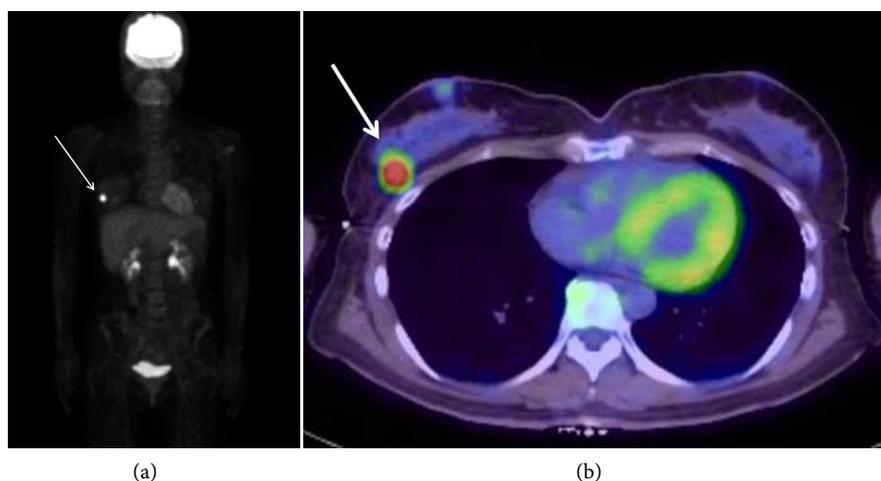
A 48-year-old woman with triple-negative invasive ductal cancer (17 mm; ER 0%, PR 0% HER2 0, Ki-67 20%, nuclear grade 3, T1cN0M0). (a) ^{18}F -FDG PET MIP image. (b) Axial PET/CT image. SUVmax value was 14.1.
